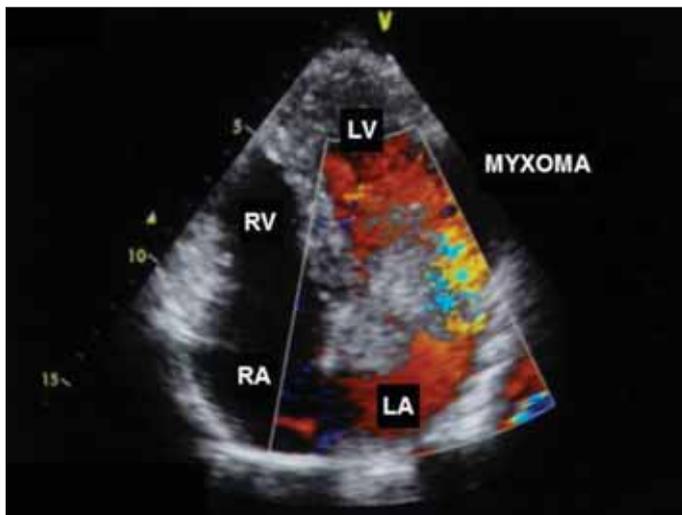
Color flow Doppler echocardiographic imaging of the partial obstruction to left ventricular diastolic filling due to the atrial myxoma
